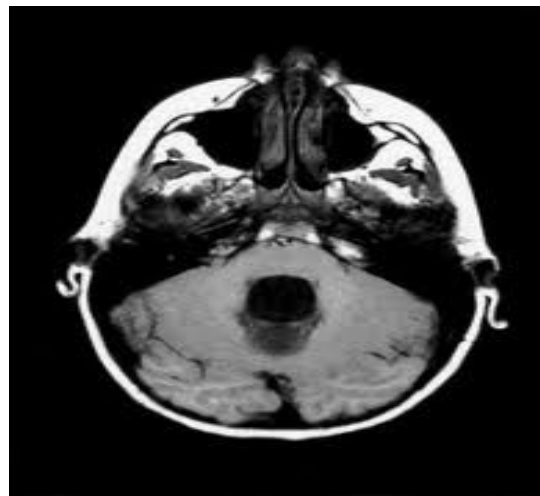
Axial MRI T1 of fourth ventricle
